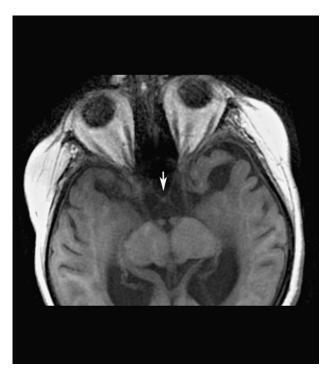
MRI T1 3D FSPGR axial image showing hypoplasia of the optic chiasm (arrow).
